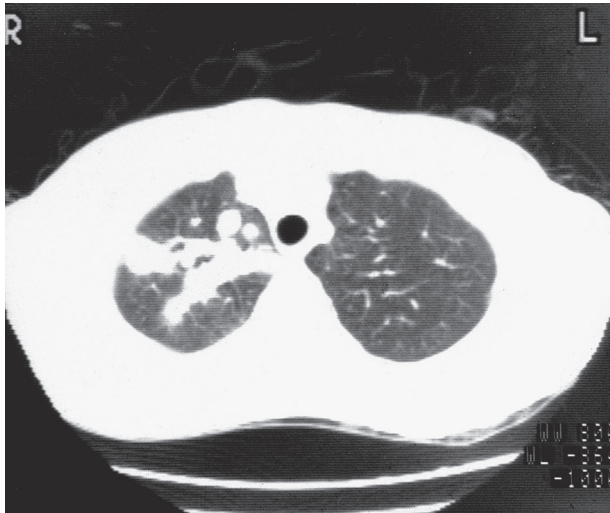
■ Computed tomography demonstrating allergic bronchopulmonary aspergillosis involving the right upper lobe.
